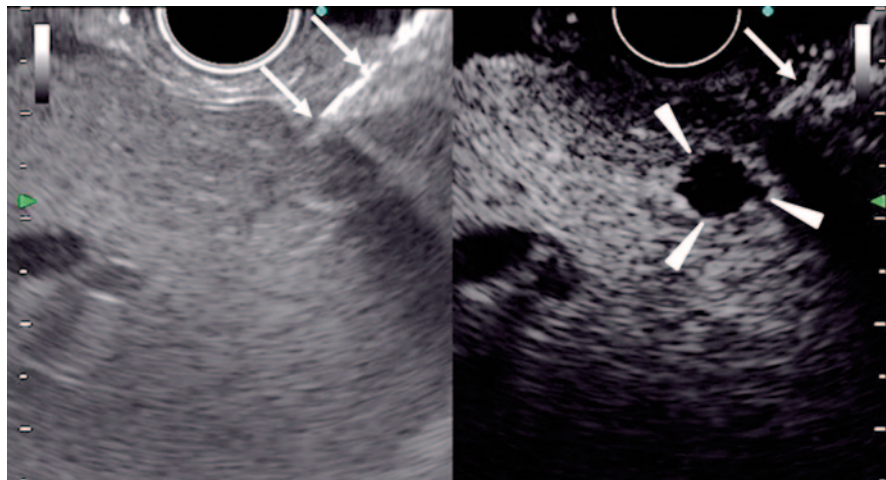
Images of contrast-enhanced EUS-guided fine needle aspiration in the liver. Conventional EUS (*left*) cannot identify a nodule, while contrast-enhanced harmonic EUS (*right*) depicts a hypovascular nodule (*arrowheads*) in the liver. A needle (*arrows*) is inserted under guidance of contrast-enhanced harmonic EUS. EUS endoscopic ultrasonography
